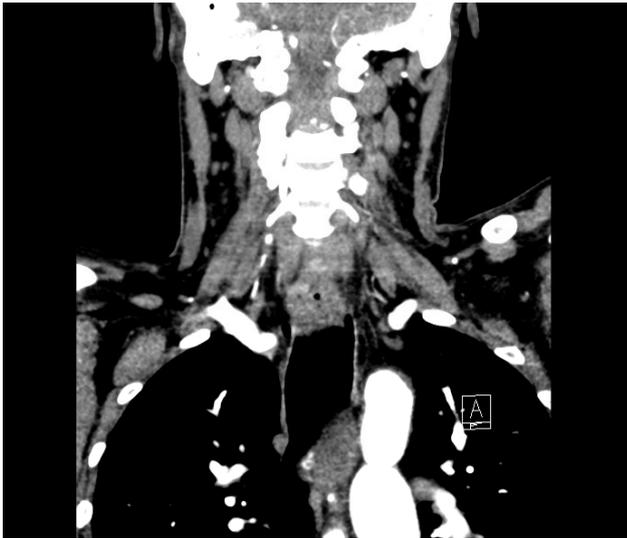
CT angiogram showing coarctation of descending aorta
